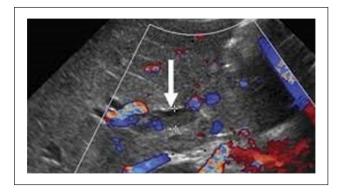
Abdominal ultrasound at day of life 20: biliary sludge in dilated common bile ductus (arrow).
